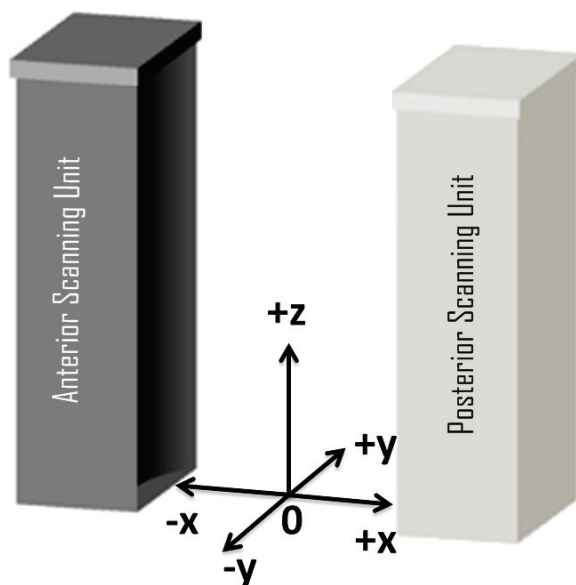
The coordinate system for describing measurements on the AIT systems. X is the dimension toward or away from the anterior (dark gray) X-ray source ($-x$ is closer to the source), and y is left or right as the screening subject faces the anterior source ($-y$ is to the left, $+y$ is to the right), $+z$ is pointing upward, with $z = 0$ at the base of the AIT system modules.
